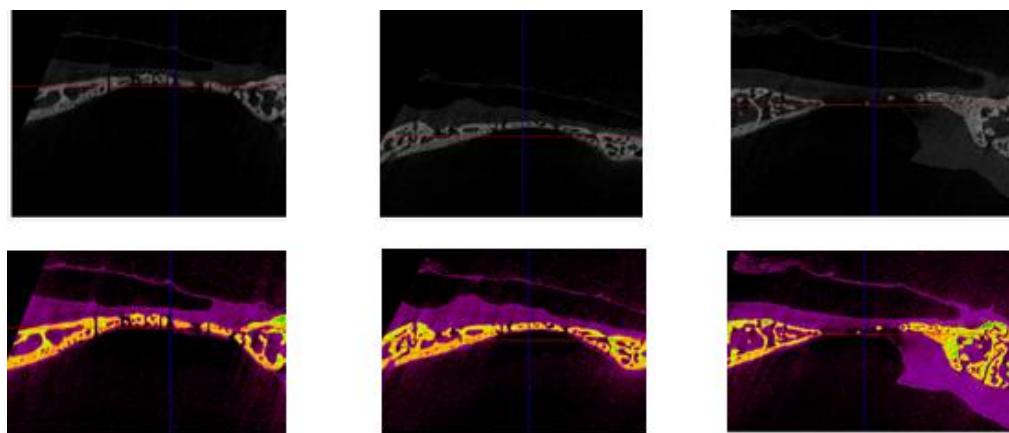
Micro CT images of three control defects at 8 weeks.
